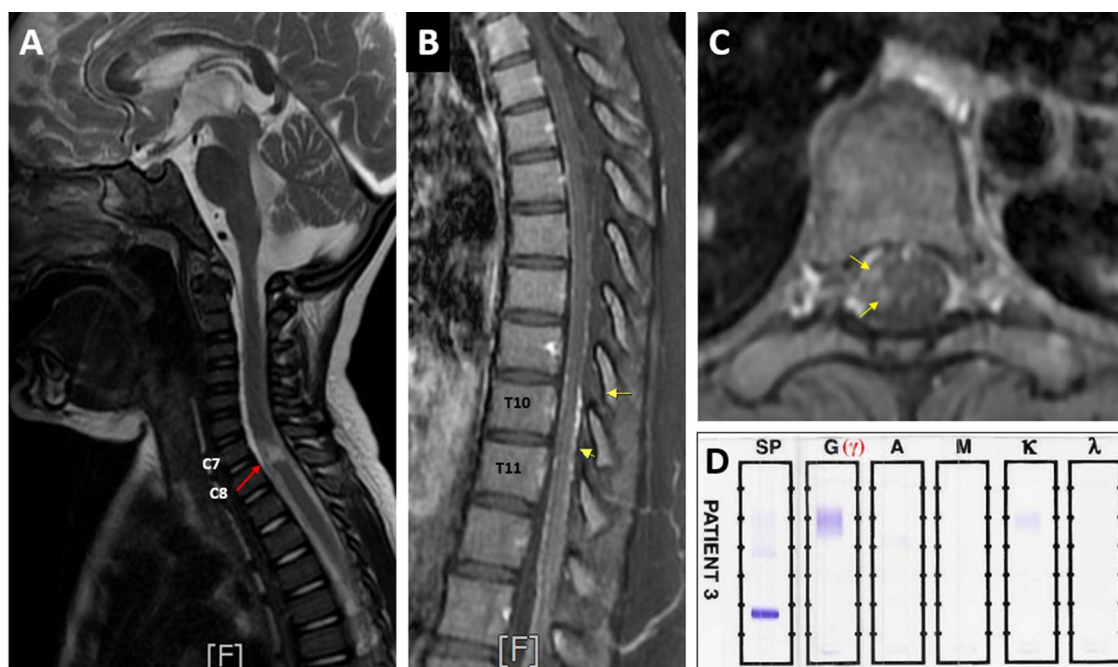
MRI and Electrophoresis Findings in Patients with Traumatic Injury (A) and Guillain-Barre Syndrome (B–D): (A) The Sagittal T2-weighted MRI of a 3-year-old boy who suffered from a traffic injury. The red arrow indicates a visible injury at the C7–C8 vertebral level, suggesting a spinal cord injury secondary to the accident. (B) The Sagittal T2-weighted MRI of a 17-year-old girl with GBS. Yellow arrows highlight spinal nerve root enhancement at the T10 and T11 vertebral levels, indicating inflammation and demyelination associated with GBS. (C) Yellow arrows in the Axial T2-weighted MRI indicate nerve root enhancements, consistent with the inflammatory process of GBS. (D) The gel of cerebrospinal fluid protein electrophoresis shows an abnormal gamma (γ) band, indicative of an immune response, the autoimmune nature of GBS. MRI, Magnetic Resonance Imaging; GBS, Guillain-Barre Syndrome; T2W, T2-Weighted
